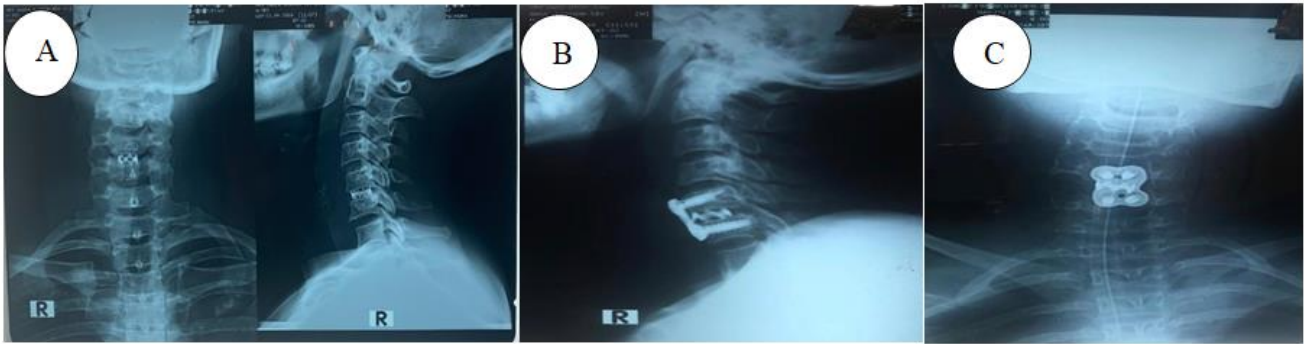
(A,B,C): Images of postoperative X-ray of the cervical spine showing a titanium mesh cage.
